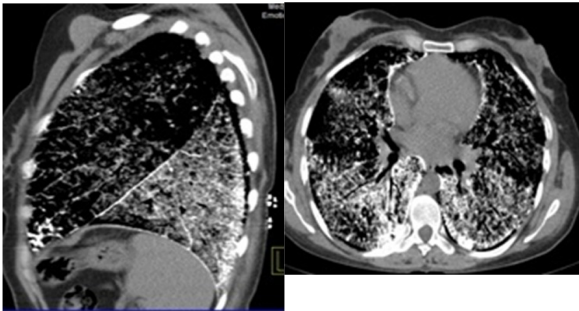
HRCT showing miliary calcification distributed all over both lungs with predominant basal and posterior distribution as well as along parietal and mediastinal pleura with black pleural line.
